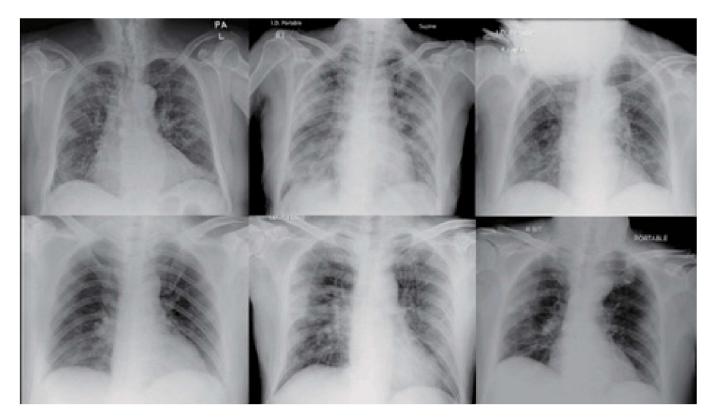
Non-specific chest radiographs in 9 confirmed cases at PMH. 10
